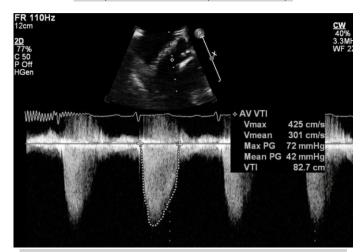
Doppler tracings from the patient, the aortic continuous wave (CW) recording shows a peak gradient of 72 mm Hg and a mean gradient of 42 mm Hg. These findings are consistent with severe aortic stenosis.
